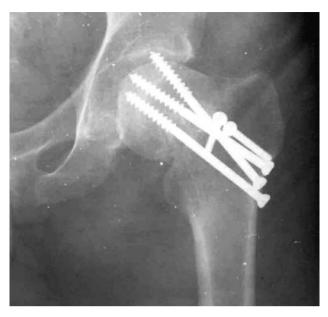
Radiograph at 1-year follow-up of a patient with varus union.
